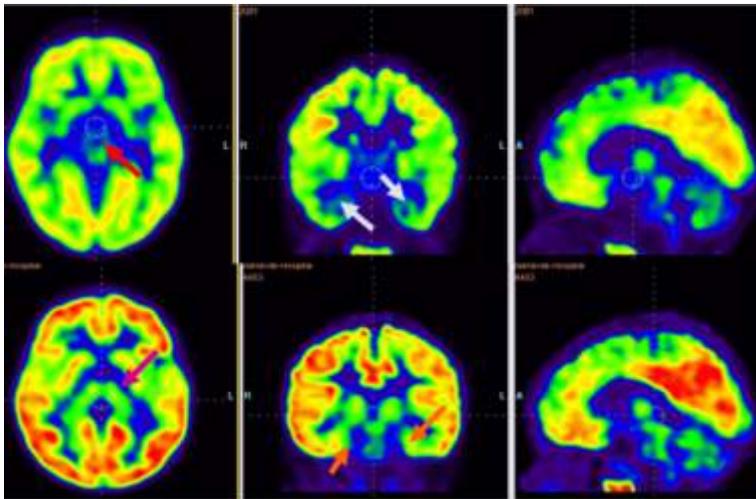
The top row indicates the PET CT scan brain image before stem cell therapy showing reduced metabolism in thalamus (red arrow), mesial temporal structures (white arrow); Below row indicates improved 18F-FDG metabolism after therapy in thalamus (pink arrow), mesial temporal structures (orange arrow).
